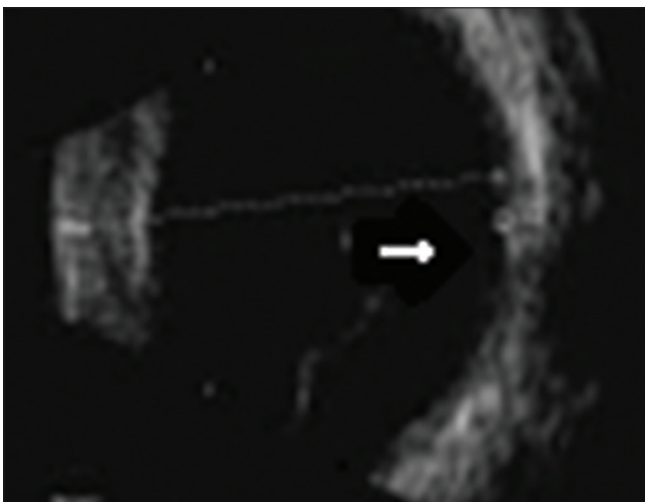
Ultrasonography right eye showing subtle retinochoroidal elevation noted posteriorly in the superotemporal quadrant with moderate surface and internal reflectivity with a peripapillary choroidal thickness of 1.8 mm
